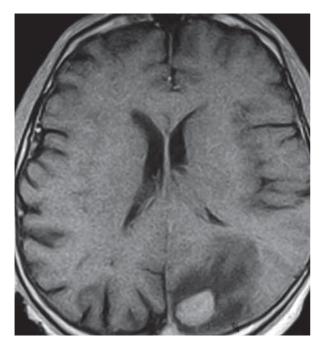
MRI revealed an oval-shaped well-circumscribed tumour (15×25 mm in diameter) surrounded by brain oedema
